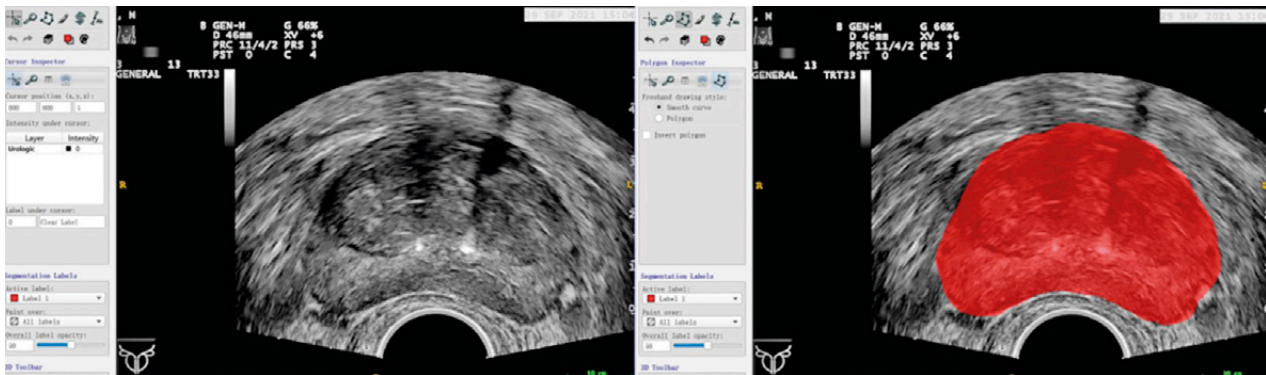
An example of region of interest (ROI) delineation on transrectal ultrasound (TRUS) imaging in ITK-SNAP software.
